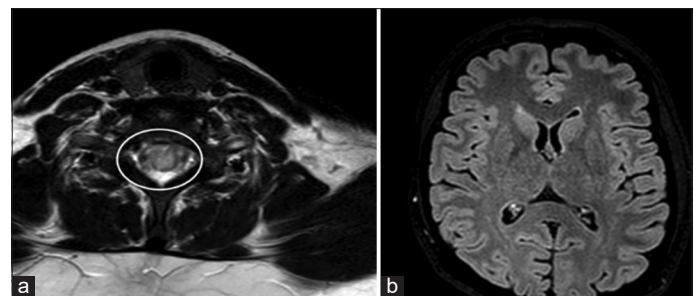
Magnetic resonance imaging cervical spine T2 axial sections showed cord hyperintensity (a) while brain T2 axial section was normal (b)
